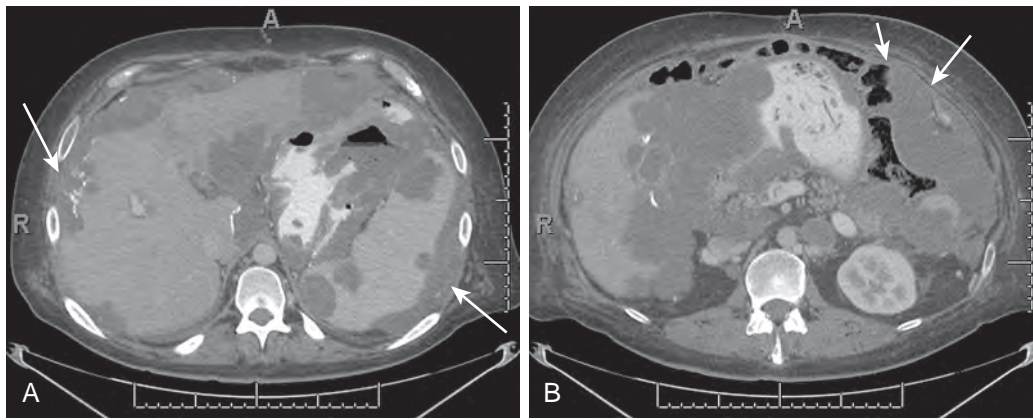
Metastatic mucinous appendiceal carcinoma. Axial CT demonstrating mucinous implants causing scalloping of the liver and spleen (arrows) with thin calcifications (A) and with mucinous implants causing mass effect (arrows) on bowel loops (B).
